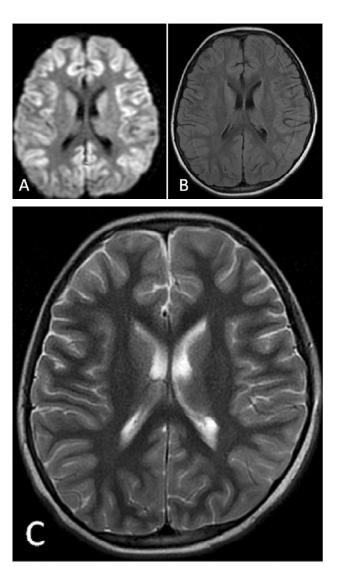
A 15-year-old male experienced sudden cardiac arrest in which her blood pressure decreased to non-palpable for 10 min. Diffusion-weighted image (A) shows restricted diffusion along the cortical and sub cortical regions of bilateral cerebral hemispheres. Axial FLAIR (B) and axial T2W (C) images show no obvious signal abnormality in the corresponding areas. Acute HIE findings are more conspicuous on the diffusion-weighted images than on the FLAIR and T2W images.
